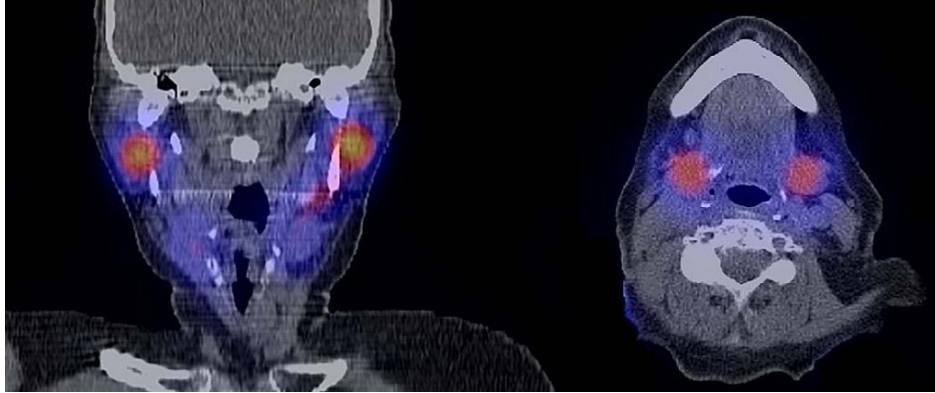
Uptake of radioiodine in the parotid (left panel) and submandibular (right panel) glands on the SPECT-CT scan, performed 7 days after radioiodine therapy.
